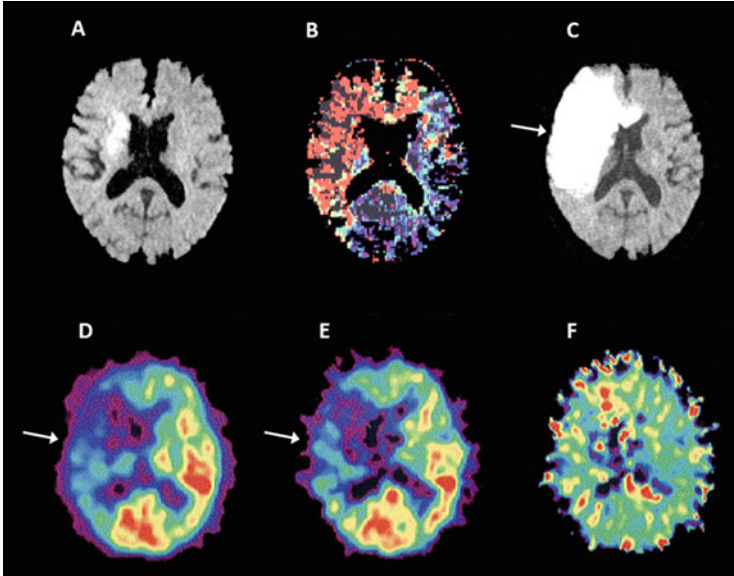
Metabolic penumbra in acute brain infarction. (a) DWI of MRI obtained 4 h after onset, (b) perfusion-weighted image (PWI) obtained 4 h after onset, (c) DWI obtained 3 days after onset, (d) CBF obtained 3 h after onset, (e) $CMRO_2$ obtained 3 h after onset, and (f) OEF obtained 3 h of onset in a patient with right ICA embolic occlusion. An MRI examination indicated PWI–DWI mismatch in the territory of the right ICA. DWI on day 3 indicated an evolution of the infarction within the mismatch. The initial PET examination indicated that the PWI–DWI mismatch lesion exhibited reductions in CBF and $CMRO_2$ associated with misery perfusion (increased OEF, *white arrow*). The PWI–DWI mismatch corresponded to suppressed energy metabolism that was still higher than the threshold for ion pump failure (Reprinted from *Brain Mapping: An Encyclopedic Reference*, Vol. 3/1st edition, Arthur W. Toga (Editor in Chief), *Hemodynamic and Metabolic Disturbances in Acute Cerebral Infarction* (title)/*Clinical Brain Mapping* (chapter), written by E. Shimosegawa, p. 829–838, 2015, with permission from Elsevier)
